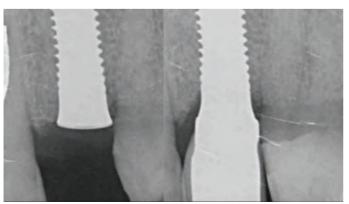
Radiograph immediately after implant installation (left) and with final rehabilitation (right)
